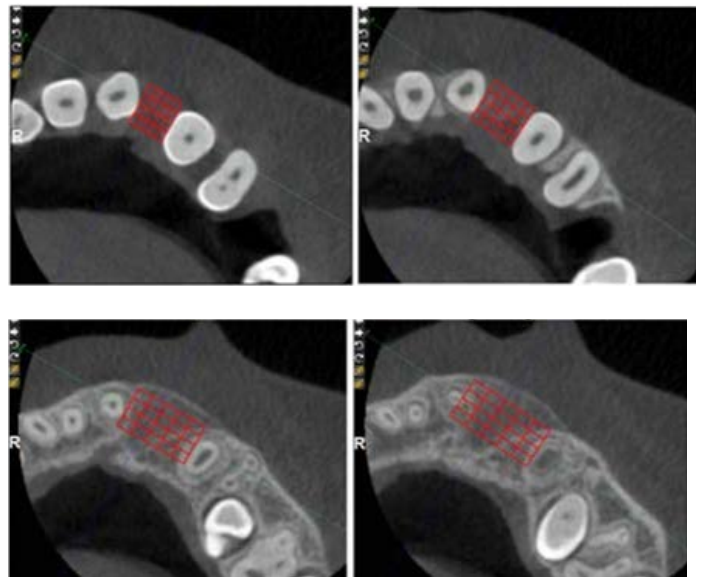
These are the CBCT images 3 months after alveolar bone graft of one patient. The score of labiolingual alveolar bone grafted thickness at CEJ level = 1, 3 mm apically to the CEJ = 1, 3 mm coronally to the apex of root = 4 and the root apex = 4.
